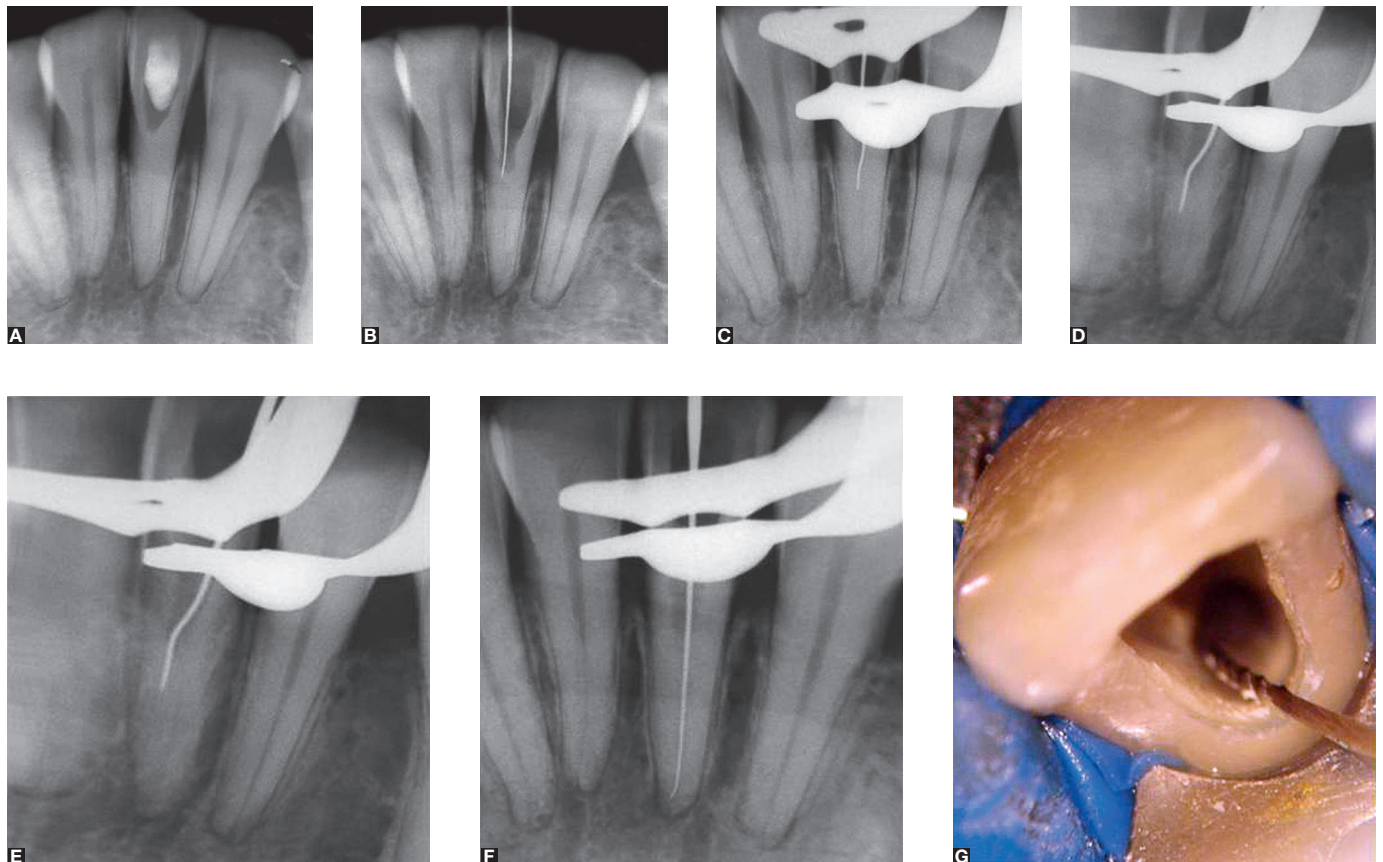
(A) Preoperative radiograph. (B) A mesial deviation can be observed. (C) The file was inserted 1-2 mm apically. The mesial deviation persisted. (D) After correction in the file position, it was inserted 1-2 mm apically. Centered radiograph shows the file in the correct mesio-distal position. (E) However the distally angulated radiograph shows that the file is labially dislocated. (F) After correction in the file position, the root canal space was reached. (G) File placed in the canal.
